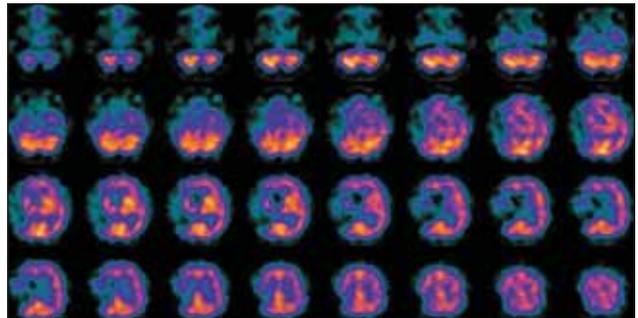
Transaxial brain perfusion 99mTc-HMPAO SPECT images taken one year later. There is no significant difference in brain perfusion in other cortical and subcortical regions. Left cerebellar perfusion is normalized with resolution of crossed cerebellar diaschisis.
